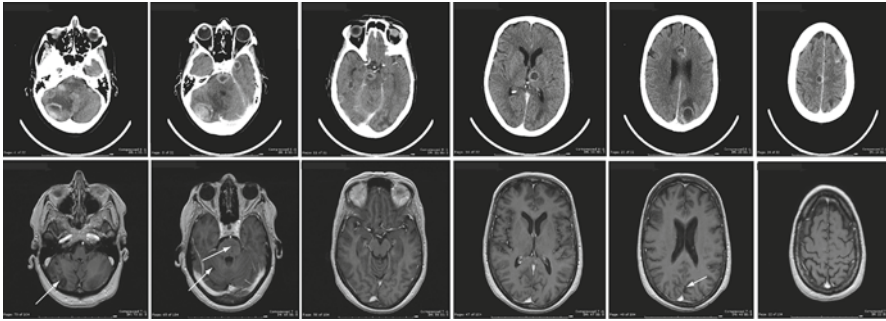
Sixty-two-year-old woman with an initial presentation of headache, nausea, and dizziness. A CT scan revealed the presence of multiple brain lesions (*upper row*). Systemic investigation revealed the presence of a pulmonary nodule and of numerous abnormal lymph nodes. A biopsy of one of these lymph nodes revealed the diagnosis of an oat cell carcinoma. The patient was exposed to eight cycles of intra-arterial chemotherapy and presented a complete response (CR) (*lower row*). The white arrows depict the areas of hypointense signal related to encephalomalacia. These regions correspond to areas where significant tumor nodules were present prior to treatment; these nodules have now receded, thus producing encephalomalacia
